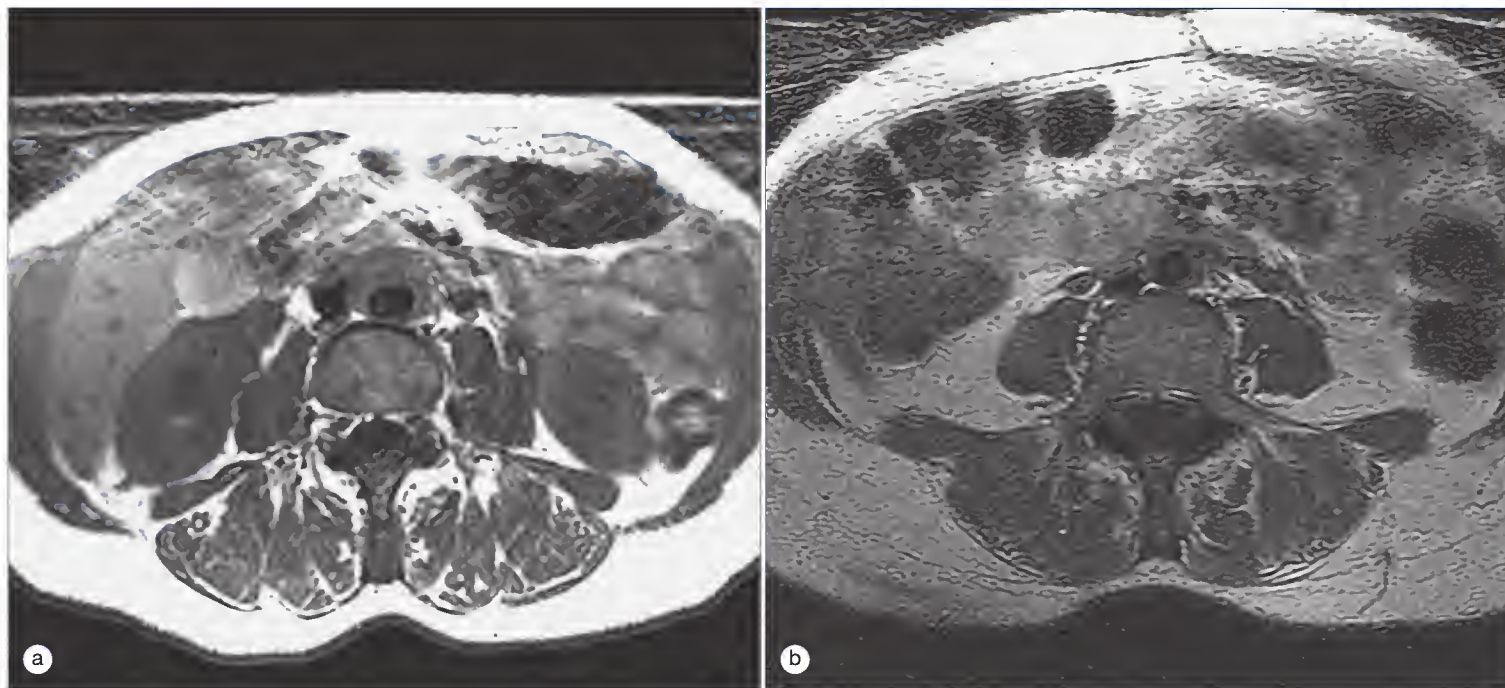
Retroperitoneal fibrosis. (a) At the time of presentation for back pain, the patient had extensive fibrosis in the retroperitoneum, as seen in this computed tomographic image. The fibrosis encases the paravertebral muscles. (b) After several months of corticosteroid therapy (1 mg/kg/day of prednisone), the patient's fibrosis had improved significantly.
